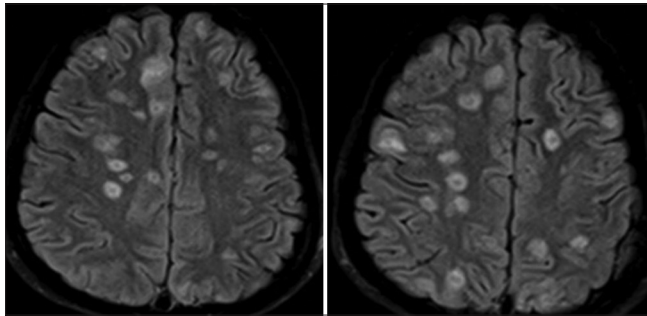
Multiple, small, well-defined, ring-enhancing lesions of varying sizes in the both cerebral and cerebellar hemispheres with involvement of deep gray matter and midbrain. Lesions show the rim of T2-weighted hypointensity and central hyperintensity with perilesional edema and diffusion restriction
